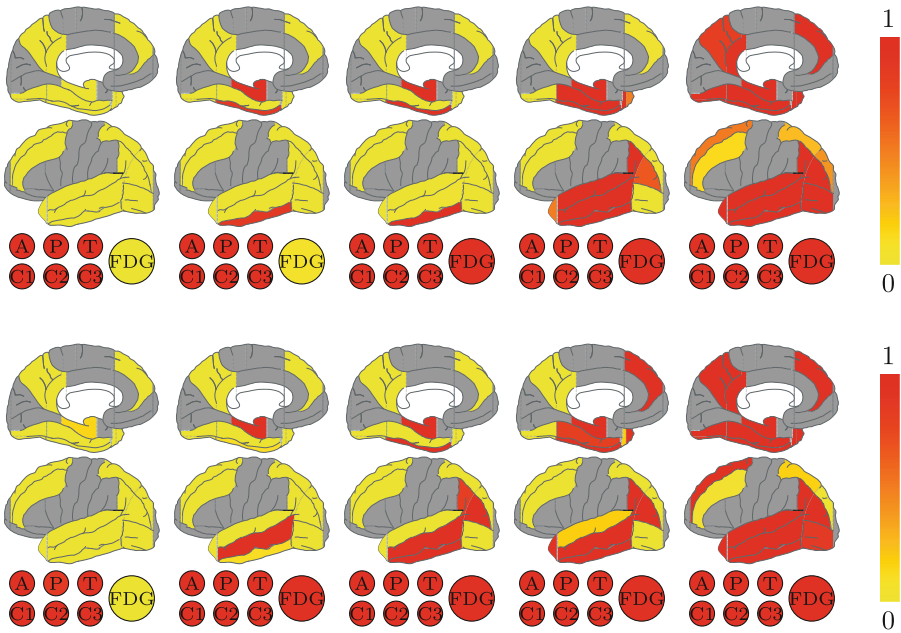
Comparison of the central ordering estimated by the event-based model (top) with the generalised Mallows model (bottom) (see key in Fig. 2). We display the results for six stages: stage 6, 12, 18, 24 and 36, where each stage number corresponds to the number of biomarkers that have become abnormal. Each biomarker (brain region, CSF, cognitive test or FDG-PET) is coloured according to the proportion of the population in which it has become abnormal by a particular stage along the central ordering. This proportion is estimated for the event-based model by the number of MCMC samples (Fig. 1), and for the generalised Mallows model by the probability (calculated using the central ordering π and spread θ) of an event appearing at or before a particular stage. This proportion ranges from 0 in yellow to 1 in red. Regions not included in the model are shown in grey. At each stage yellow biomarkers can be interpreted as being normal, red biomarkers as being abnormal, and orange biomarkers as varying in whether they have become abnormal across the population (Color figure online).
